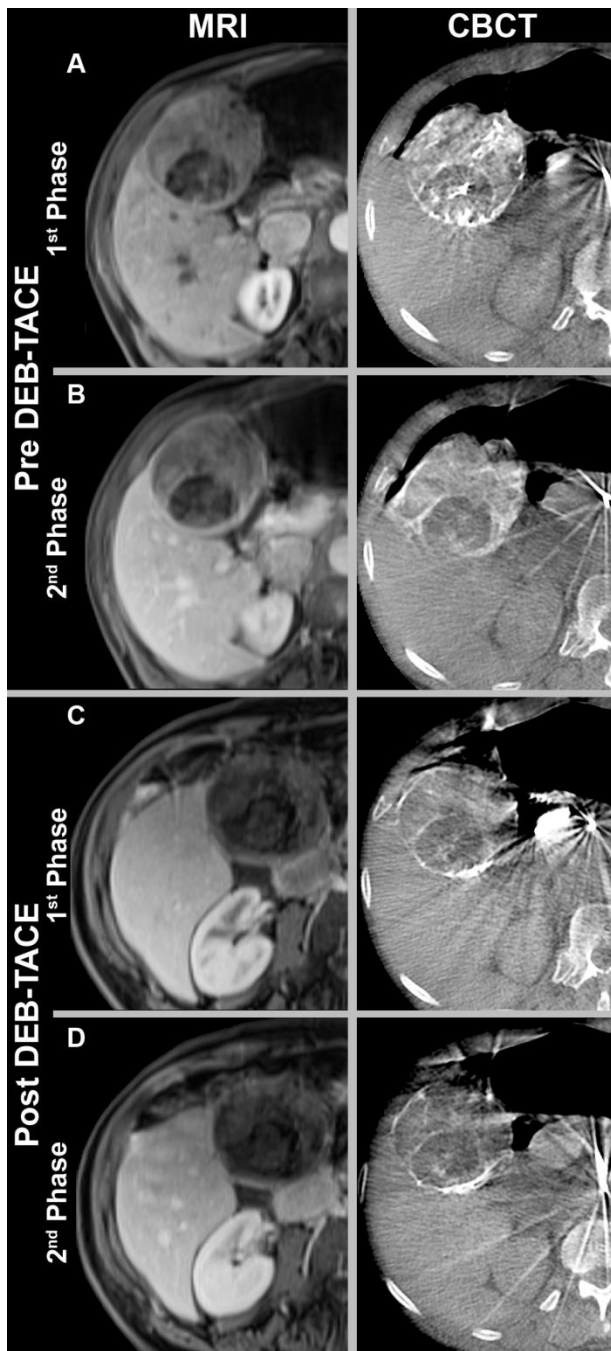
A–D, Representative enhanced first and second phase MR (left) and CBCT (right) images from a 58-year-old man with right-lobe HCC secondary to hepatitis C virus. MR images were acquired approximately 1 month before and after DEB-TACE therapy, while dual-phase CBCT images were acquired prior to and immediately following DEB-TACE. A, First phase baseline pre-DEB-TACE images. Left: A 32-mm mass in right lobe shows 75% enhancement (arrows). Right: Mass shows almost similar enhancement (80%) (arrows). B, Second phase baseline pre-DEB-TACE images. Left: Mass shows partial wash-out (50% enhancement) (arrows). Right: Mass shows almost same enhancement reduction (65%) (arrows). C, First phase post-DEB-TACE images. Left: Mass shows almost no enhancement (5%), tumor remains unchanged in size (31-mm) (arrows). Right: Intra-procedural mass enhancement (arrows) changed by 100%, which predicted an objective EASL response at 1 month. D, Second phase post-DEB-TACE images. Left: Mass shows almost no enhancement (5%) (arrows). Right: Intra-procedural mass enhancement (arrows) changed by 92.3%, which predicted an objective EASL response at 1 month.
